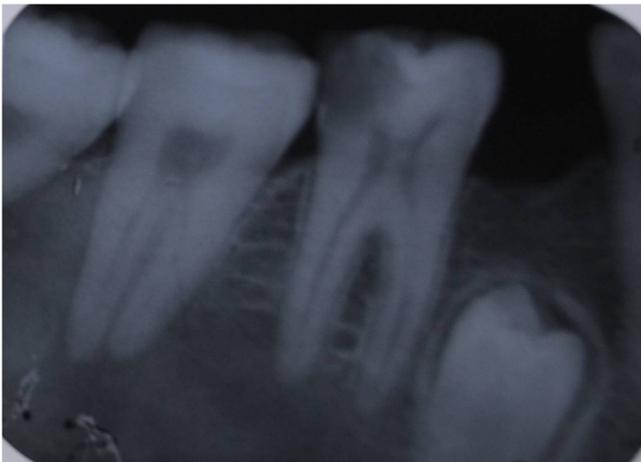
Intra-oral periapical radiograph of the patient showing presence of mixed radiopaque – radiolucent lesion in the periapical region in relation to 46, 47 with non corticated borders. Also, impacted 45 seen.
